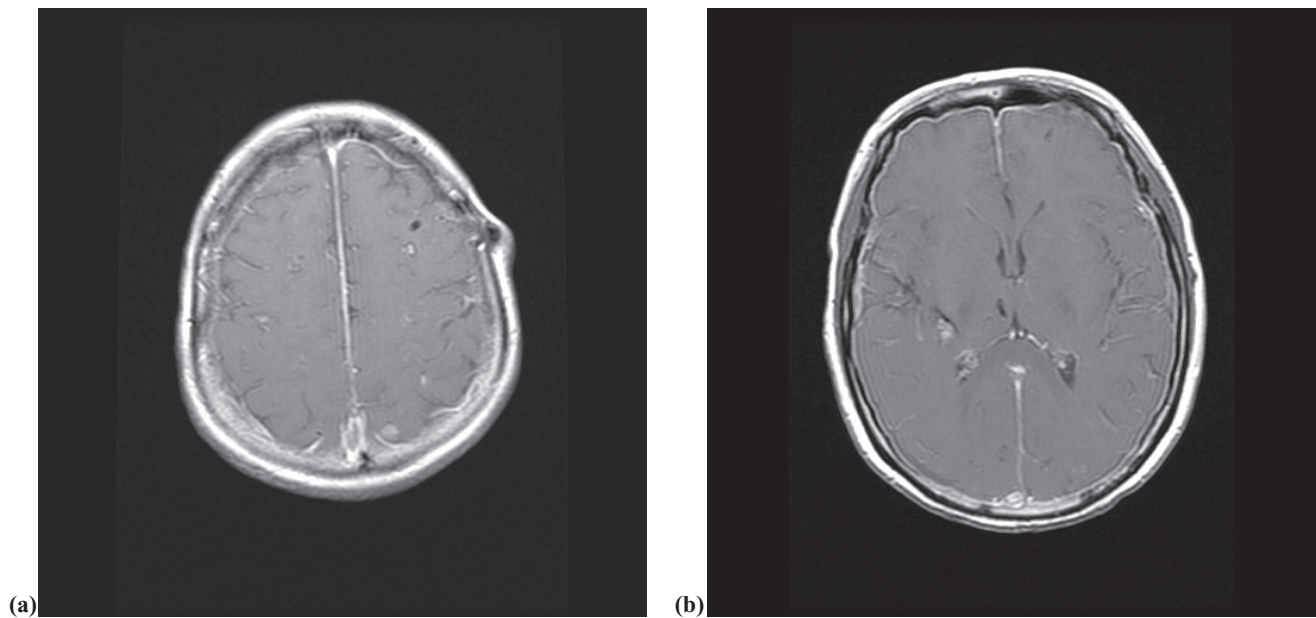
Day 69 axial post-gadolinium T1-weighted MRI after gefitinib and whole brain radiation, demonstrating resolution of multiple metastatic lesions (a) and (b). The pachymeningeal enhancement is related to ventriculoperitoneal shunting.
